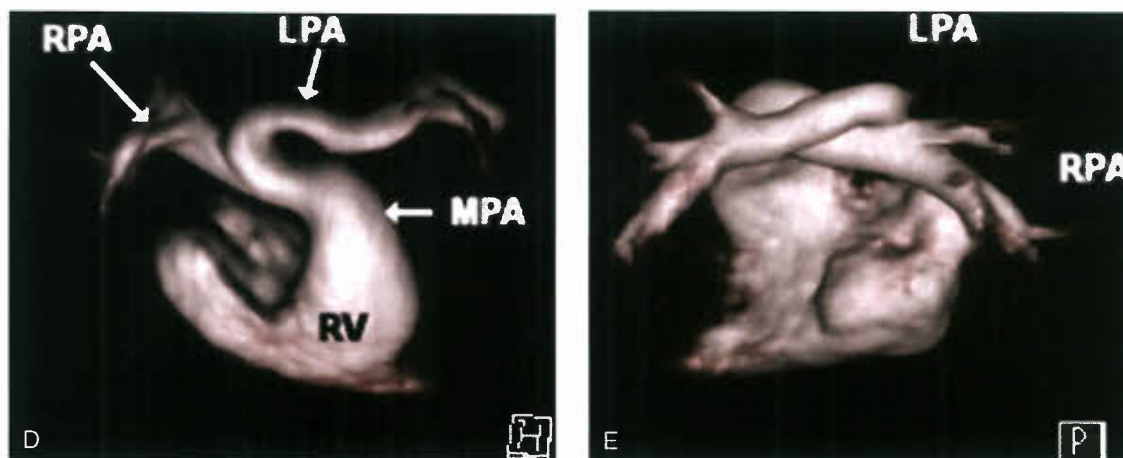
(Continued) D: 3-D surface display from gadolinium-enhanced MRI of the right heart from a different patient than (A–C). Direct cranial view showing the right ventricle (RV) and main pulmonary artery (MPA) giving rise to the RPA. Note the left pulmonary artery (LPA) taking off from the RPA and looping back around the trachea in a tight hairpin turn. E: Posterior view of the same patient as in (D). Again it is clear that the LPA arises from the RPA.
